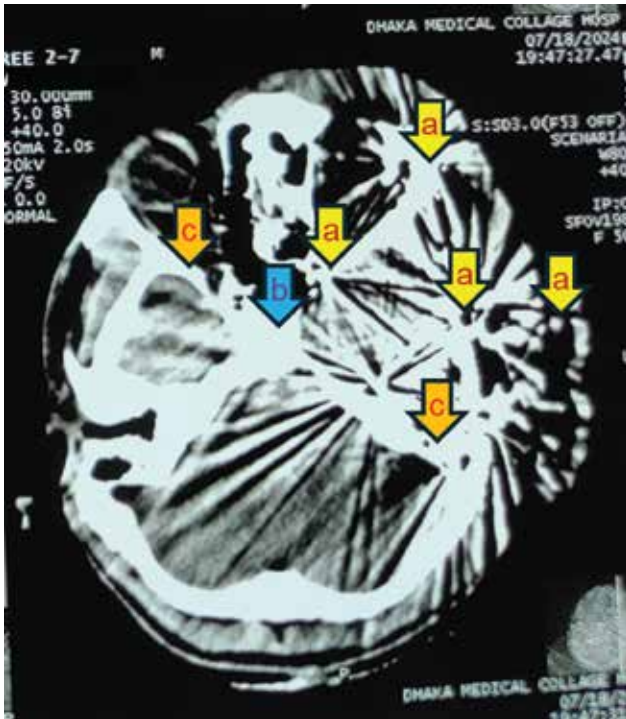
CT scan of brain with multiple intracranial shrapnel
